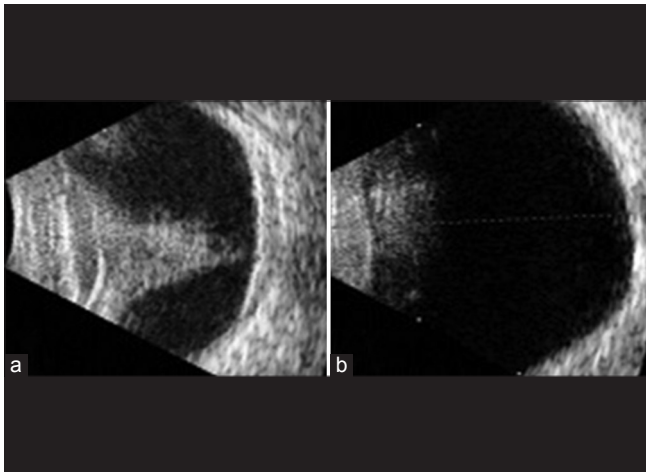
Ultrasonography B-scan showing closed funnel retinal detachment with axial length of 21.2 mm (a) in right eye and axial length of 26.3 mm in left eye (b)
